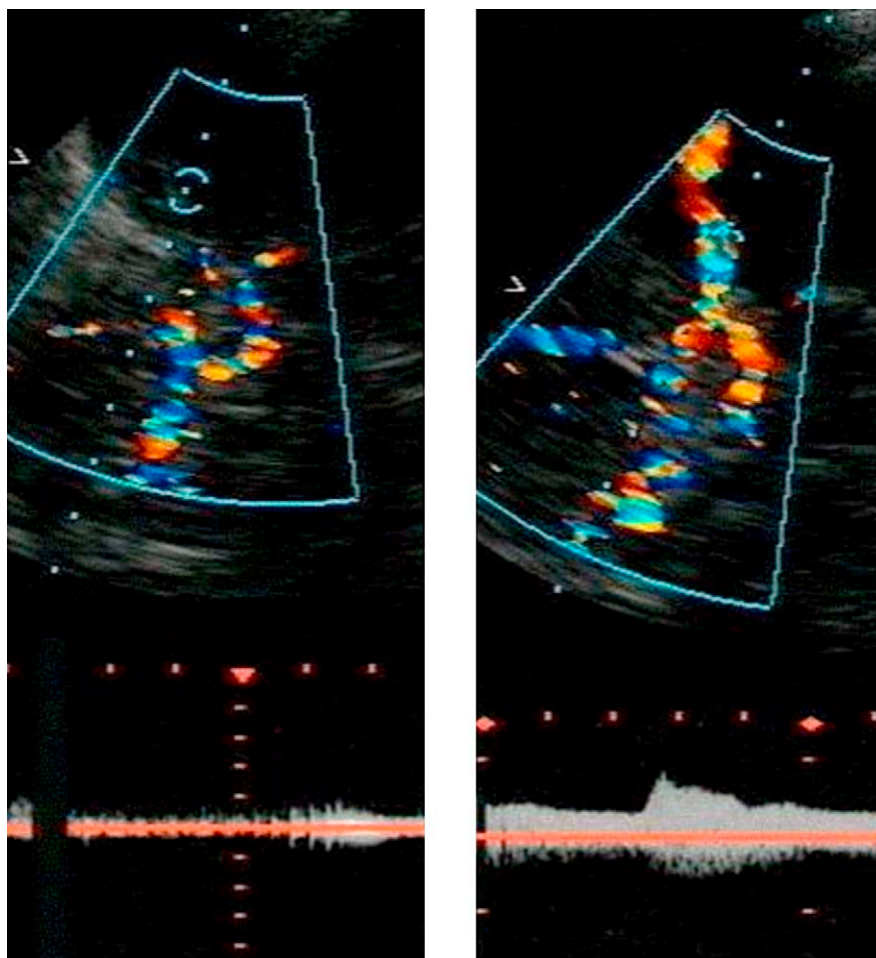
Transcranial image in color-coded mode of transcranial color-coded sonography (TCCS). Proximal middle cerebral artery (MCA) main stem occlusion (left) with complete recanalization at 1 h after intravenous (IV) recombinant tissue-type plasminogen activator (rtPA) plus sonothrombolysis (right).
